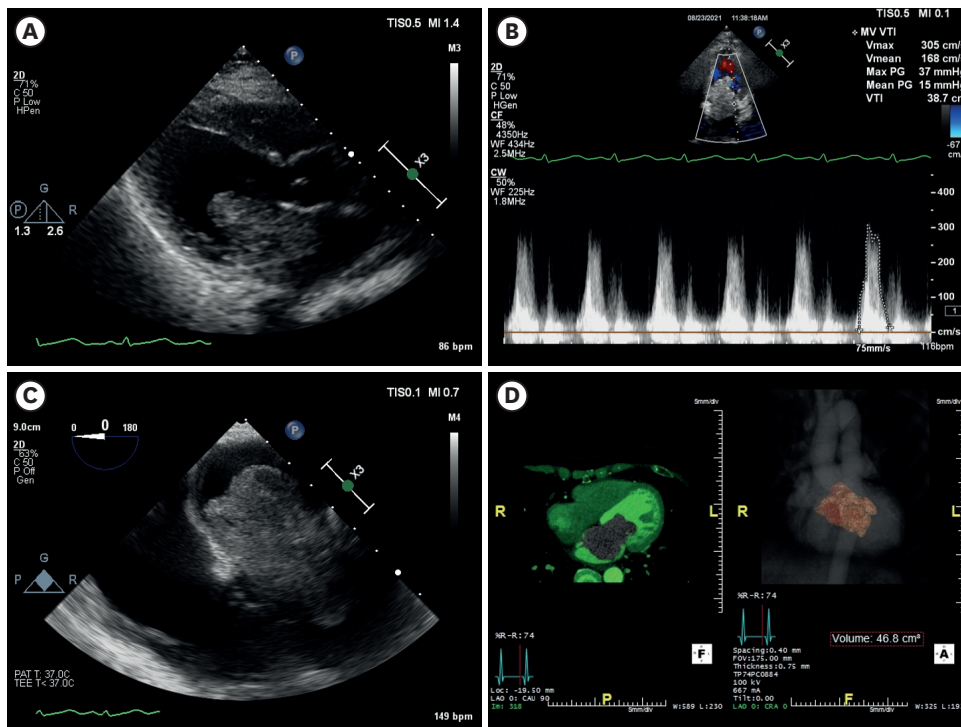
Transthoracic echocardiography demonstrated a mobile, echogenic mass in LA (A) causing severe mitral stenosis (B). Transesophageal echocardiography image of mid-esophageal 180° view showed 6.0 × 4.4 cm-sized, multi-lobulated mass attached at LA (C). Computed tomography angiography image revealed a large mass in LA (D).
